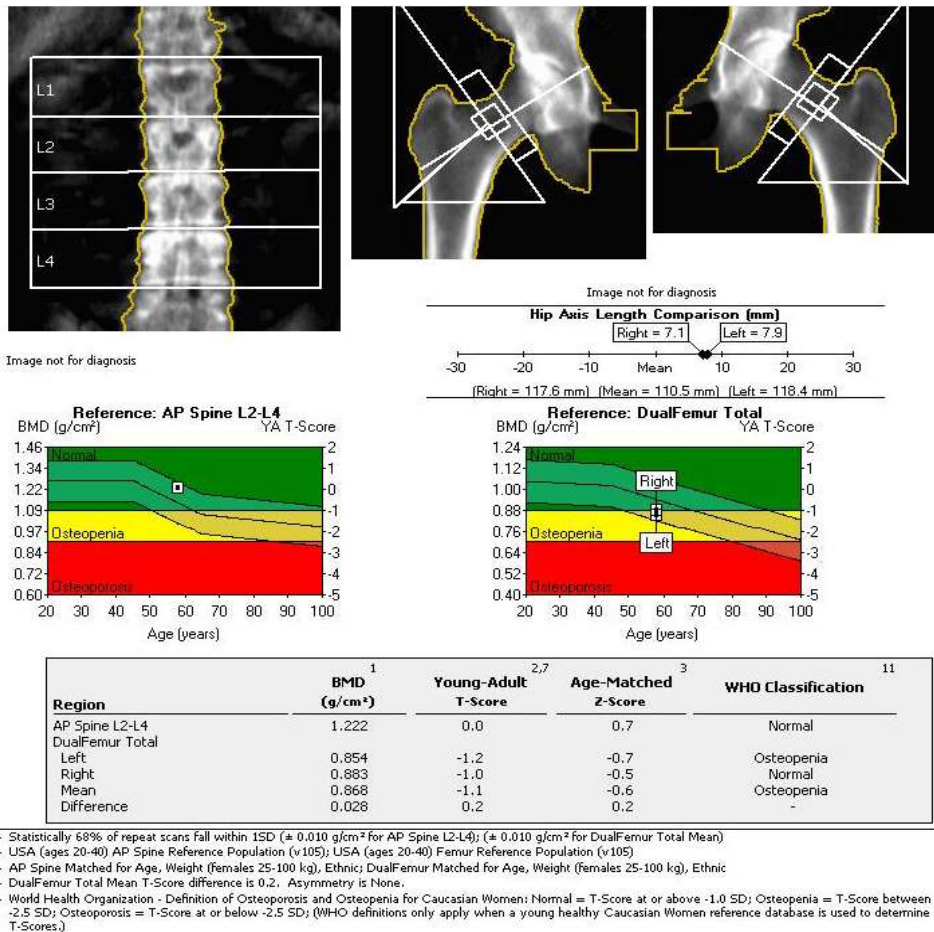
A sample dual energy X-ray absorptiometry report of a study participant. BMD, bone mineral density; AP, Anteroposterior; WHO, World Health Organization
